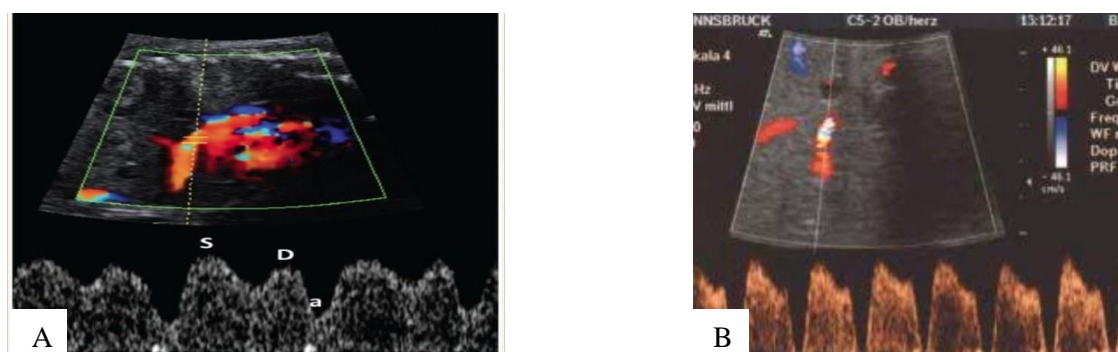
Doppler US of ductus venosus
